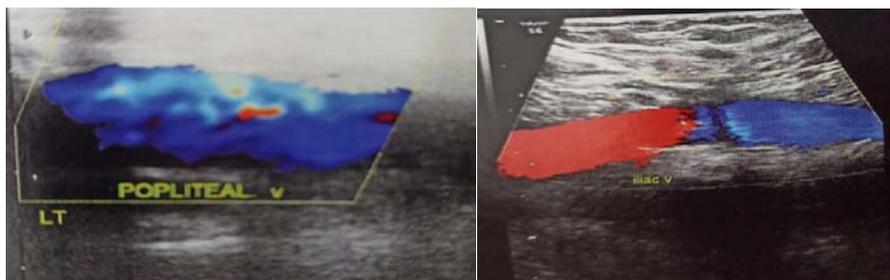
Showing Normal Popliteal and Iliac Veins on Color Doppler.
